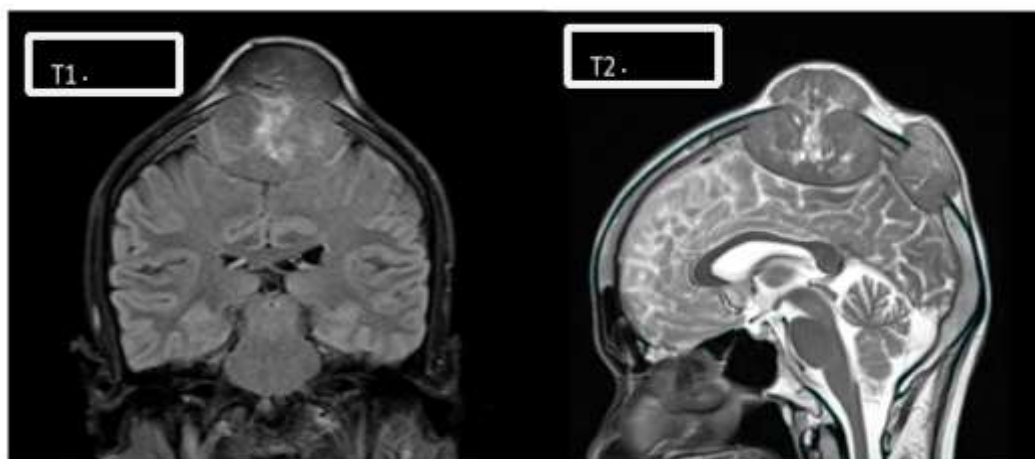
large irregular heterogeneously hyperintense lesion involving left parietal region on T2W images which appears hypointense on T1W images. The lesion shows thick irregular isointense walls. It appears bright on DWI. SWI reveal peripheral hypointense area involving the lesion.
